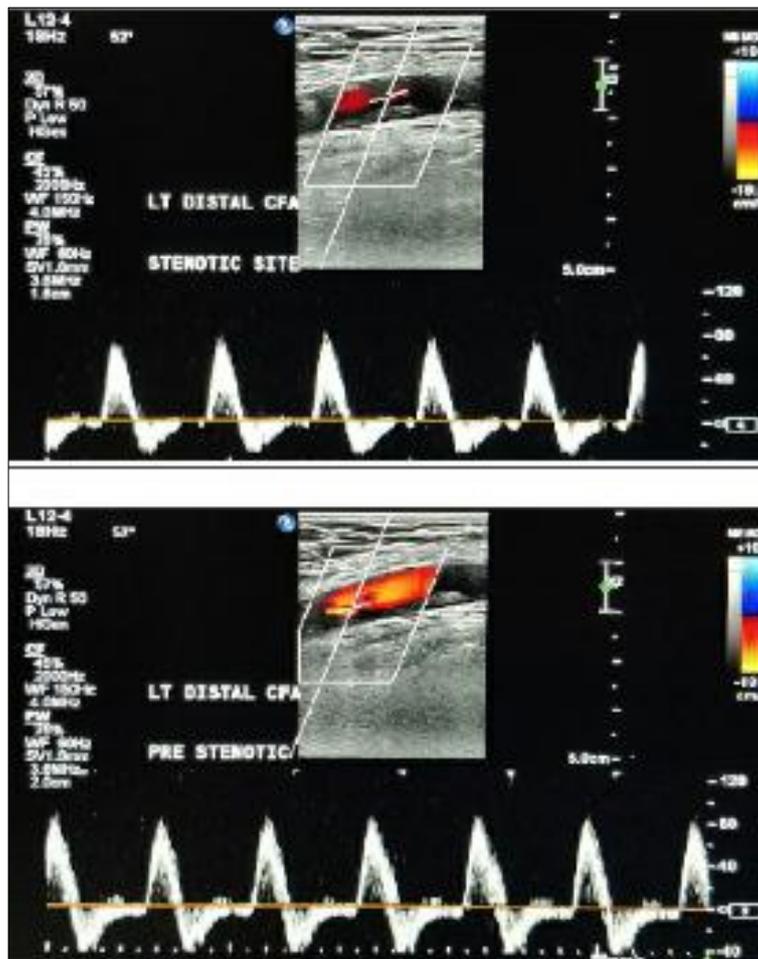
Longitudinal Color Doppler image showing evidence of moderate echogenicity plaque in left common femoral artery. PSV ratio obtained was <math><2:1</math>. Also noted, mild spectral broadening in waveform. These findings suggested mild stenosis on USG.
